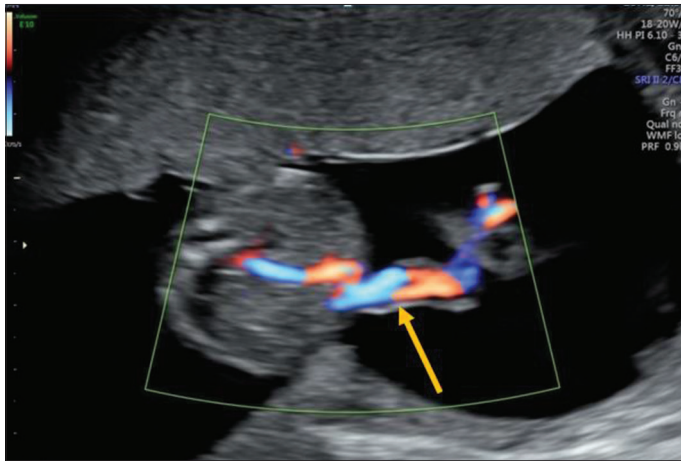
Ultrasound color Doppler in axial view. On follow up, ultrasound done at 16 weeks, arrow showing single umbilical artery in a cranial location
